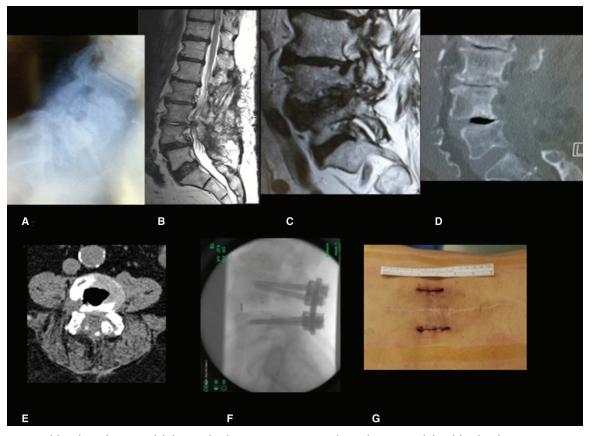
A 71 year-old male with severe debilitating back pain. Status post-traditional L2–L5 multilevel lumbar laminectomy. Preoperative (A) plain lateral radiograph, sagittal MR image (B, C), sagittal (D) and axial (E) CT showing L4–L5 grade 2 spondylolisthesis, severe bilateral foraminal stenosis, and air in the L4–L5 disc space. Postoperative (F) plain radiograph, and incision (G) after L4–L5 MITLIF. Patient made an uneventful recovery with resolution of symptoms. MITLIF indicates minimally invasive transforaminal lumbar interbody fusion; MR, magnetic resonance; CT, computed tomography.
